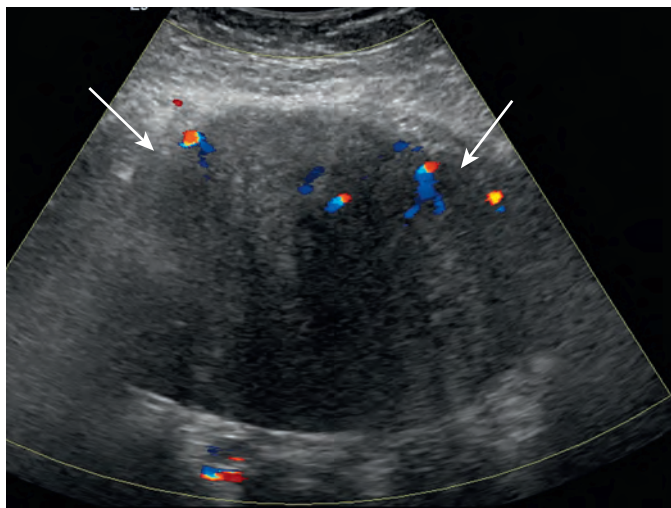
Desmoid tumor. Desmoid tumor (arrows) is a hypoechoic mass on ultrasound.
